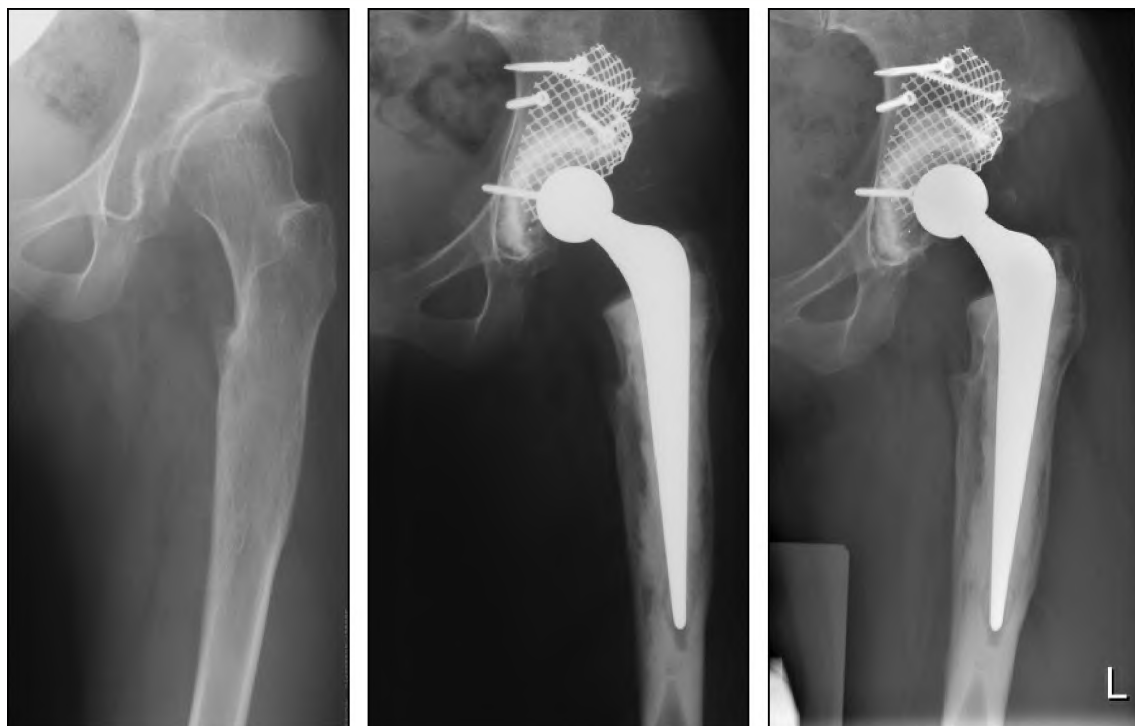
AP radiographs of a 19 years-old female with developmental dysplasia of the hip. Preoperative AP radiographs of the left hip to be reconstructed (A), immediately postoperative (B), and 7 years postoperative (C) showing a radiographically stable view.
